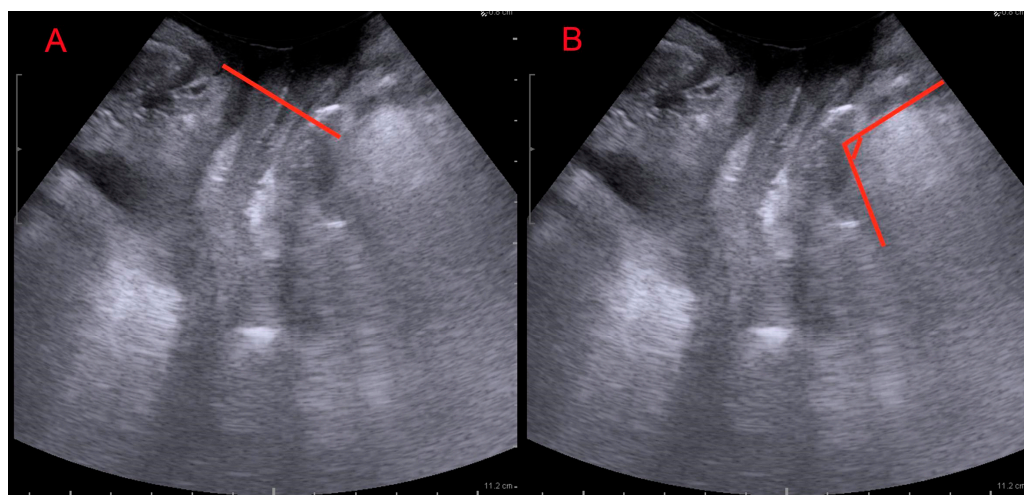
Translabial ultrasound: midsagittal view. (A): levator ani muscle minimal plane distance (LAMD) defined as the minimal distance between the hyperechogenic posterior aspect of the symphysis pubis and the hyperechogenic anterior border of the levator ani muscle just posterior to the anorectal angle; (B): anorectal angle (ARA) measured as the angle between the posterior edge of the rectum and the posterior edge of the anal canal.
